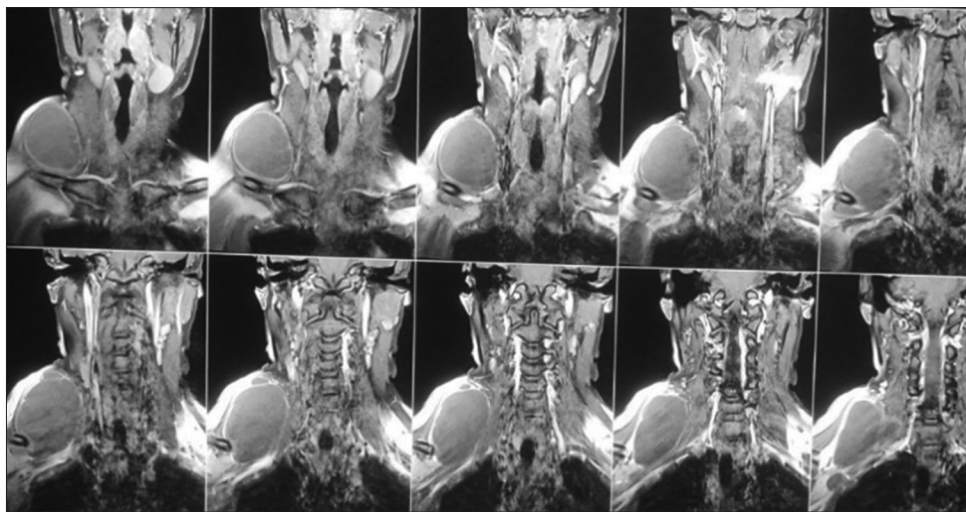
Coronal view of contrast-enhanced computed tomography.
